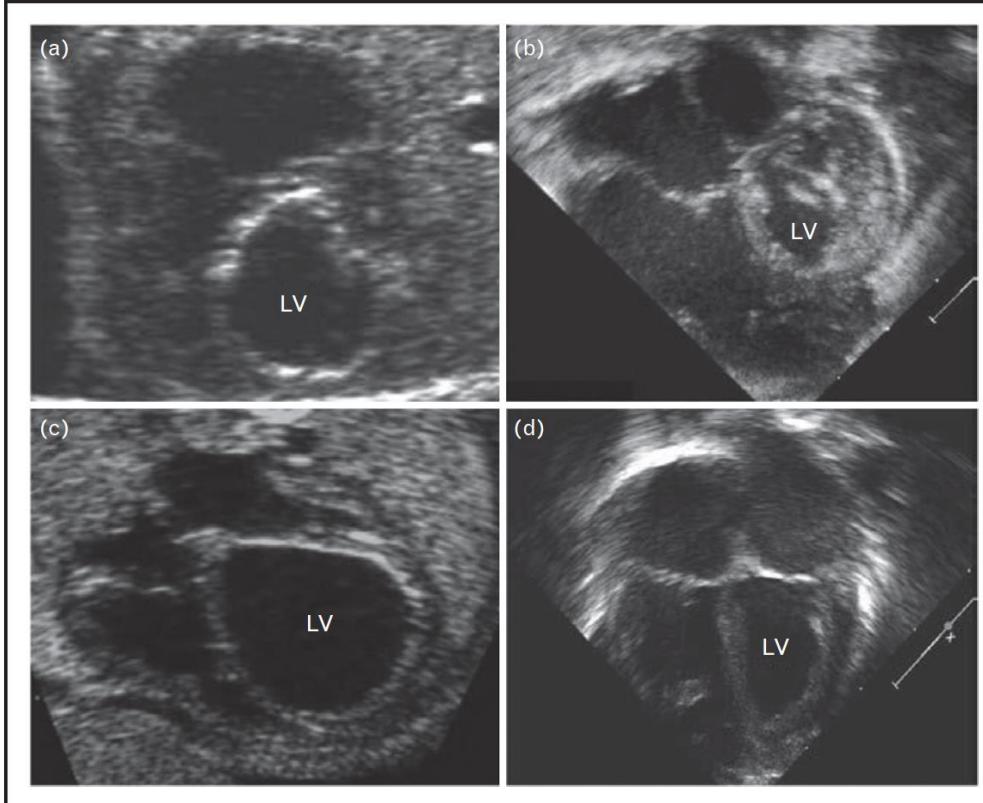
Four-chamber views of the heart are demonstrated for two patients, with the preintervention fetal echocardiograms on the left and the postnatal echocardiograms on the right. The patient depicted in the first row (images a and b) had a technically unsuccessful fetal aortic valvuloplasty and was managed as HLHS after birth, whereas the patient in the second row (images c and d) had a technically successful procedure and a biventricular outcome. (Reprinted with permission from [20^a].)
